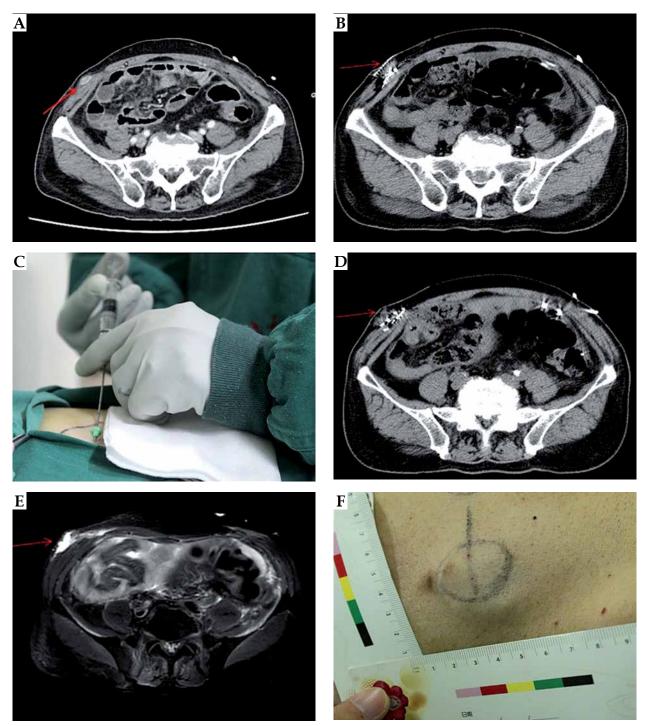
Process of hyaluronic acid (HA) injection between the tumor and skin. A) Subdermal malignant tumor on a CT scan (red arrow); B) The needle tip for HA injection was placed between the skin and the tumor (red arrow); C) HA injection; D) The new space caused by HA injection is shown in the CT image (red arrow); E) The new space caused by HA injection is shown on T2 MRI (red arrow); F) Skin appearance after HA injection
